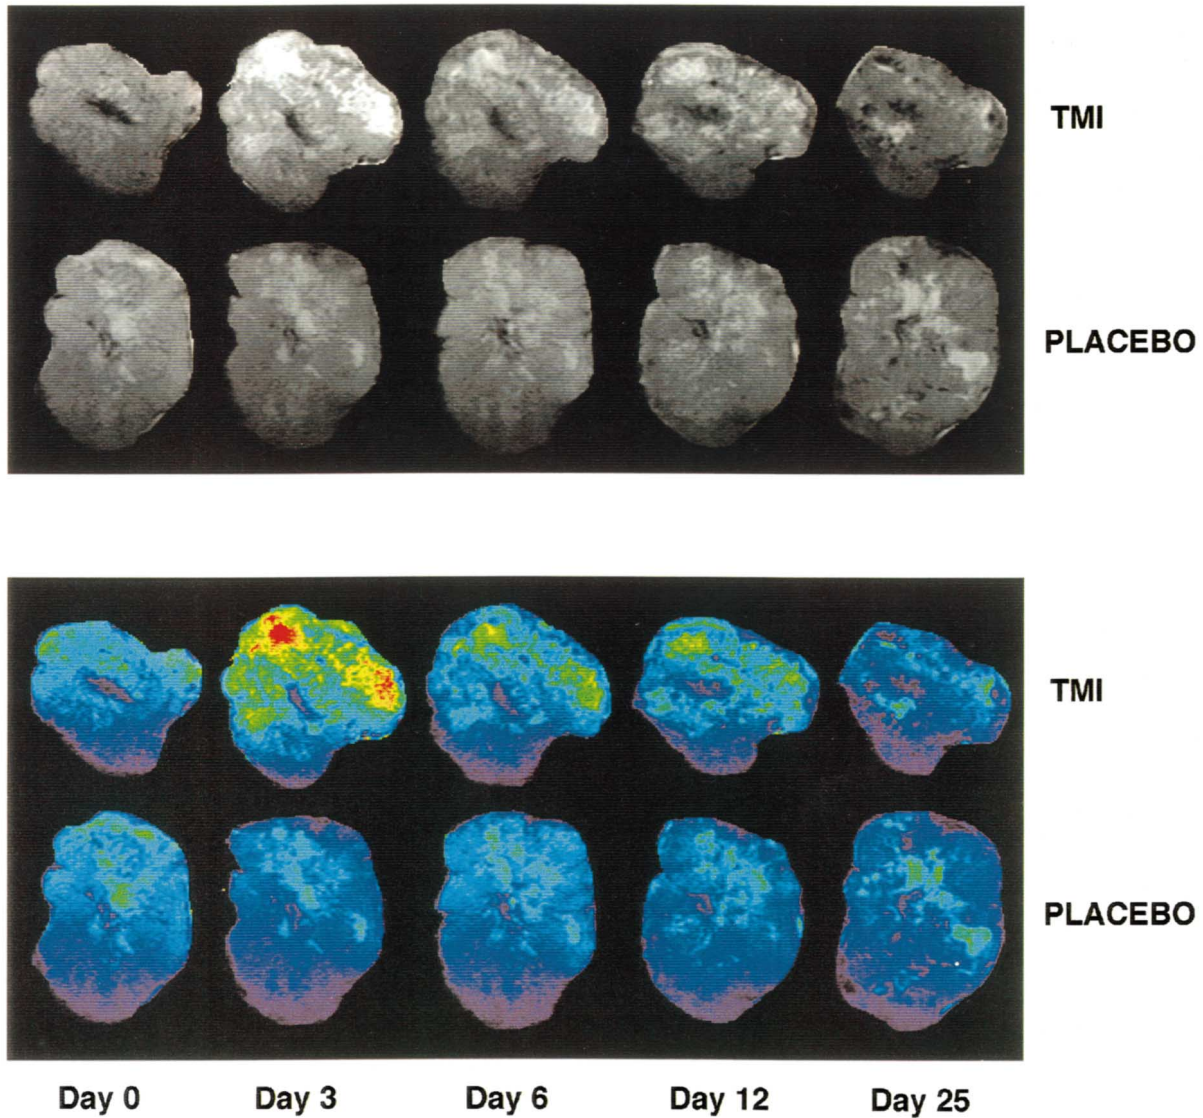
Effect of TMI or placebo on tumor pathomorphology at various time after initiation of treatment. T2-spin-echo MR images as well as color-enhanced images are presented as described in the Section 2. Necrosis is evident in bright regions of the black and white images (green, yellow or red areas of the pseudocolor images), viable areas are grey in black and white images and blue in the pseudocolor images and fibrosis (showing most prominently at day 25) is black in the black and white T2-images and dark purple in the pseudocolor renderings.
